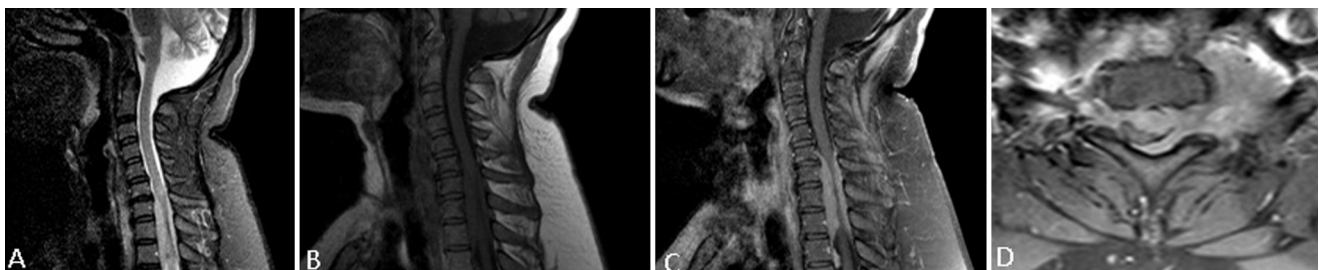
Sagittal T2-weighted (A) and sagittal T1-weighted (B) MR images show the extradural mass lesion that was hyperintense on T2-(A) and isointense on T1-(B) weighted images. The lesion shows intense and homogeneous enhancement on postcontrast T1-weighted sagittal (C) and axial (D) image.
